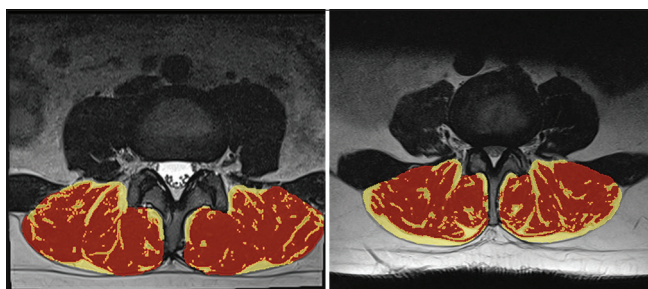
Slicer three-dimensional muscle and fat measurement on axial magnetic resonance image of two different cases. Red areas represent muscle tissue, while yellow areas represent fat tissue.
